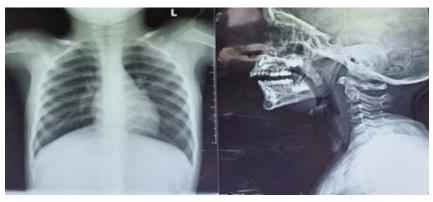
Postero-anterior chest X-ray and lateral soft tissue head and neck X-ray, no foreign body is appreciable
